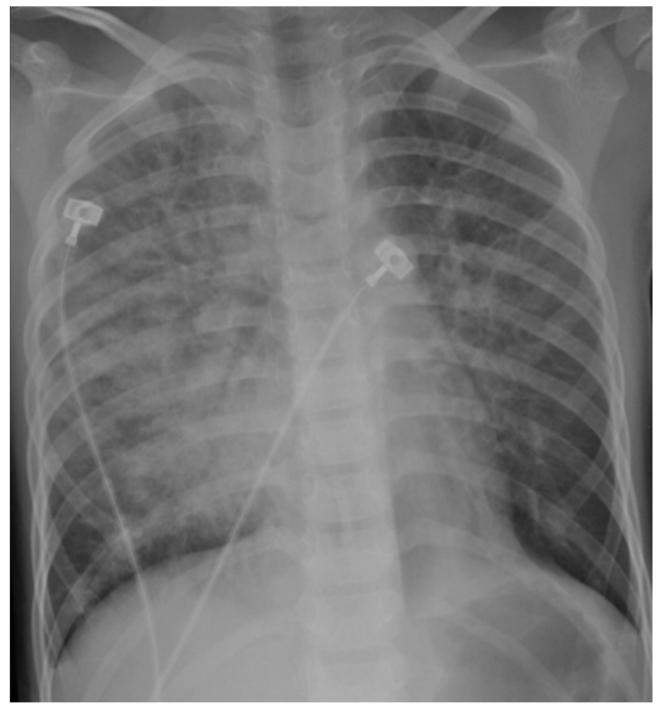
Chest radiography conducted at 2 h after injecting the contrast medium
